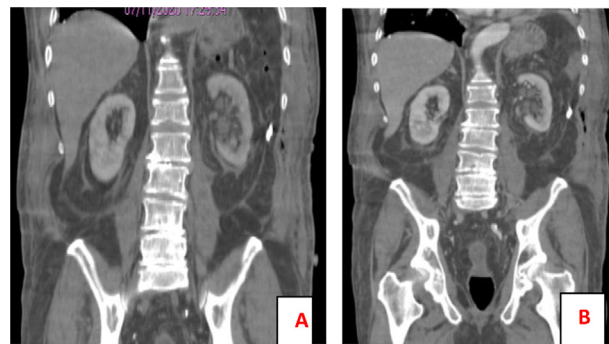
(A-B) Contrast-enhancement CT one week after the surgery (adrenalectomy), with coronal reconstructions (A-B), showed that the left retroperitoneal hematoma was in the reabsorbing phase. There were no other nodular lesions in the left adrenal region.
